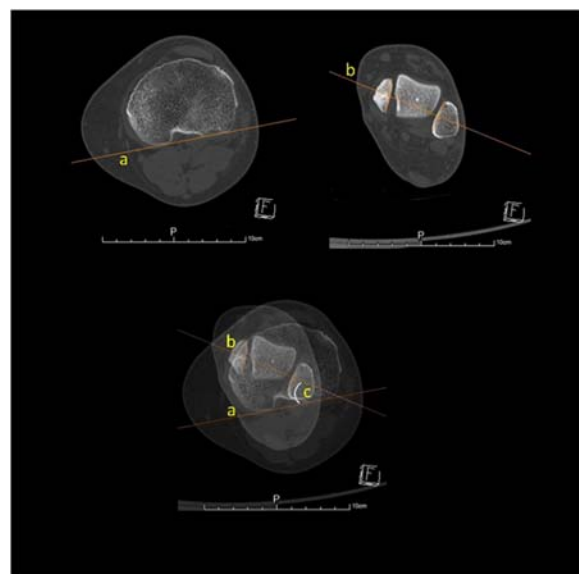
Measurement of DTR by PACS. CT scans were used to evaluate the angle between the proximal posterior tibial axis (a) and the bimalleolar axis (b). The angle (c) is the distal tibial rotation angle (DTR).
